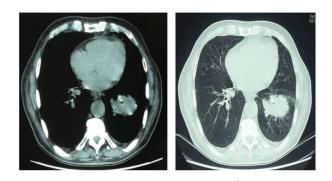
Chest CT axial view: (a) mediastinal window and (b) pulmonary window showing a mass with irregular contours of the left lung.
